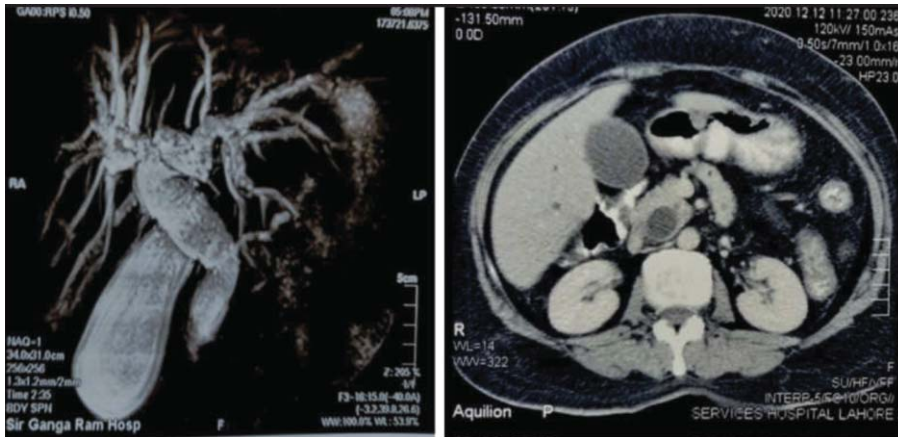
Pre-operative investigations showing Dilated CBD due to Obstruction on MRCP and Dilated CBD with Distended Gall Bladder on CT SCAN.
